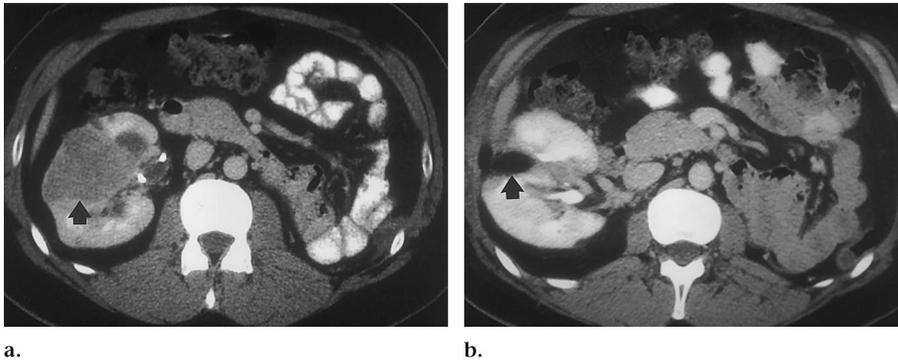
Nephron-sparing surgery in a 38-year-old man with hereditary renal cancer (VHL disease). The patient had undergone prior left nephrectomy. (a) Transverse CT image demonstrates a large mass (arrow) in the right kidney. To preserve renal function, nephron-sparing partial nephrectomy was performed and retroperitoneal fat was packed in the wound. (b) Post-operative transverse CT image demonstrates fat within the wound (arrow) at the site of disease. No recurrence has been observed during 4 years of observation.
